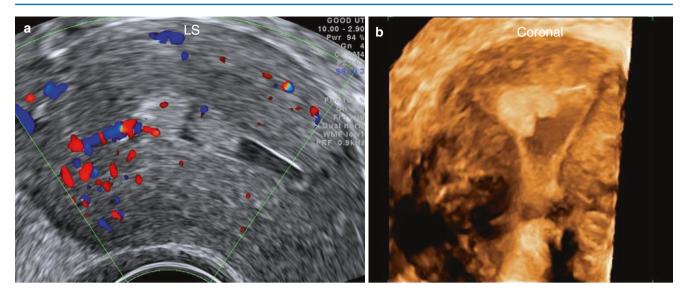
Blood in the endometrial cavity enhancing delineation of two endometrial polyps (a) on 2D with Doppler and (b) on 3D
